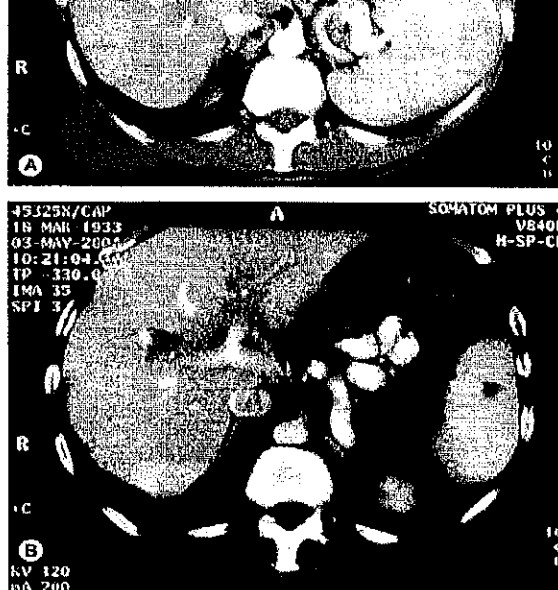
Abdominal CT scan (A) in July 2000, showing splenomegaly and extensive lymphomatous infiltration at the porta-hepatis, and (B) in May 2001, showing over 50% reduction in disease bulk.
